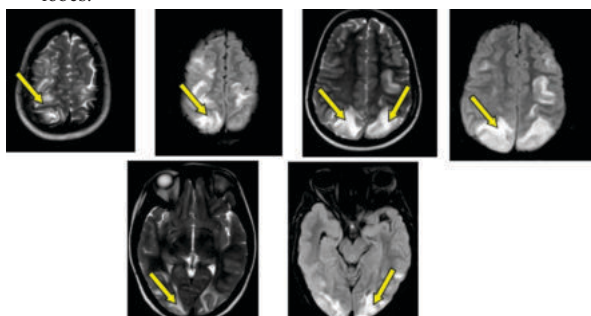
17 years patient with 3 episodes of convulsion in 1 week. MRI shows T2/FLAIR hyperintensity is seen in the subcortical white matter of bilateral high frontal and parieto-occipital lobes - Posterior reversible encephalopathy syndrome
